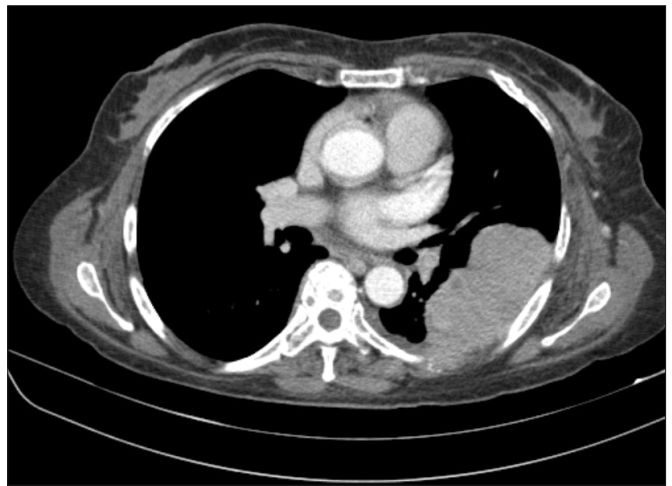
A left posterior-lateral, pleural-based mass with lung infiltration, without marked rib destruction. The lesion on the computed tomography scan was reported to be suggestive of lung cancer, but ultimately proven to be a plasmacytoma.
